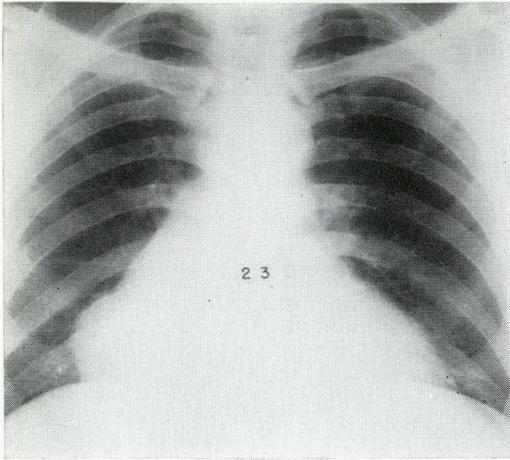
Case 6—thymic cyst. Preoperative chest radiograph.
